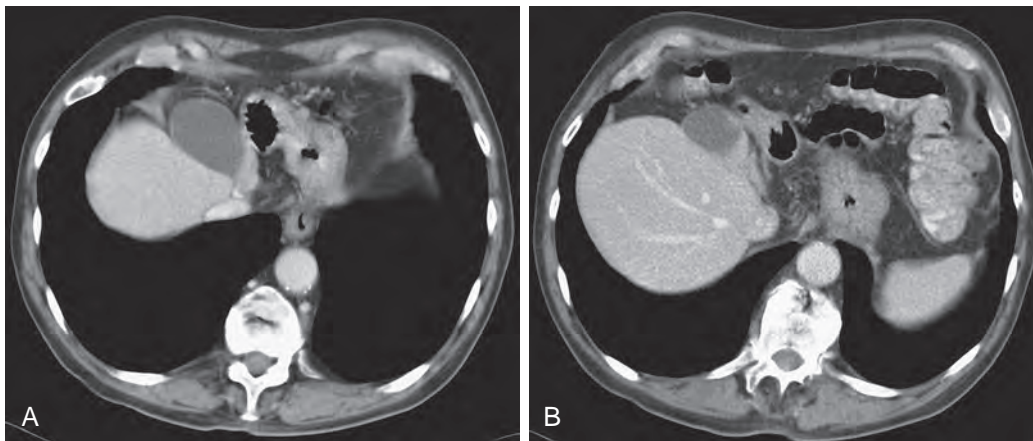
Agenesis of the left lobe. A. In this contrast-enhanced CT study of the upper abdomen, there is total agenesis of the left lobe with the gallbladder being seen anterior and medial to the right lobe. The gastric fundus is displaced medially. B. Notice absence of the left hepatic vein, while the middle and right hepatic veins are opacified.
